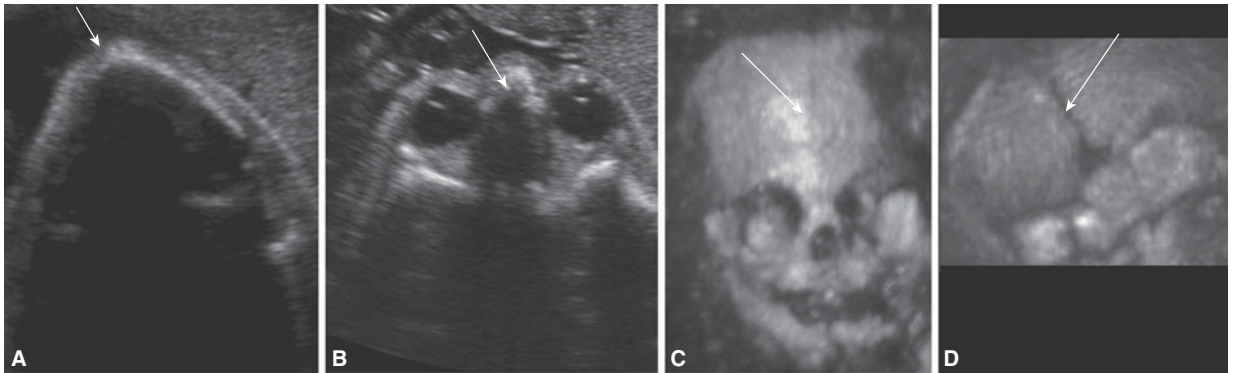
Trigonocephaly in a second-trimester fetus. (A), (B) 2D US demonstrating triangular forehead without evidence of central metopic suture and mild hypotelorism (arrows). (C) 3D US in maximum rendering mode of the skull confirming mild hypotelorism and no evidence of metopic suture (arrow). (D) 3D maximum mode rendering of the skull in a lateral projection demonstrating a patent coronal suture (arrow). (Reproduced, with permission, from *Visual Encyclopedia of Ultrasound in Obstetrics and Gynecology*, www.isuog.org.)
